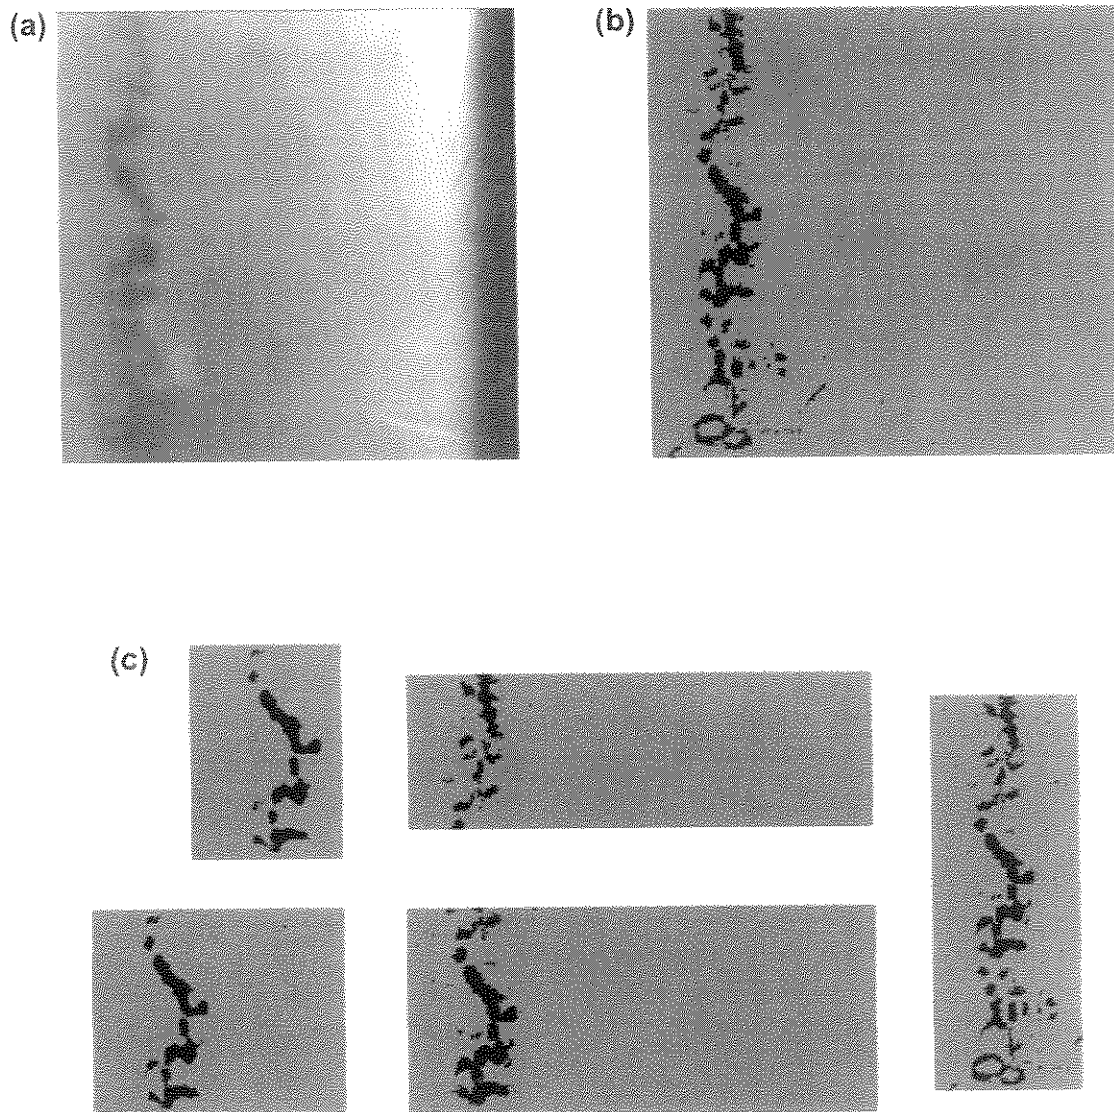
Trial Case 3 (X-ray Level 5) (a) after scanning, (b) after Transform processing, and (c) several alternate selection areas
